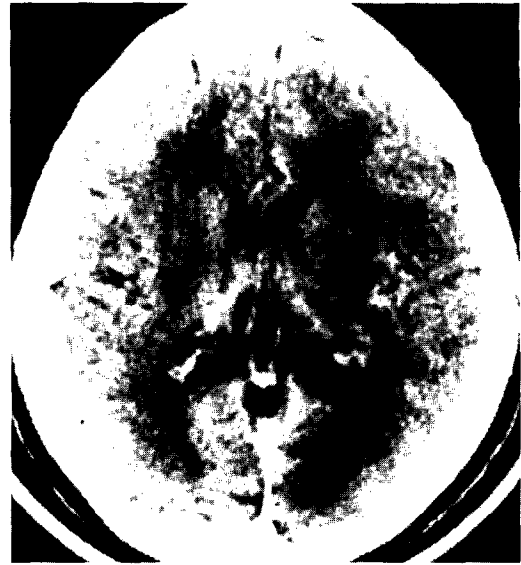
Axial brain CT shows a radiolucent area (infarct) extending from splenium (anteriorly) to visual cortex (posteriorly) on left side. Patient manifested alexia without agraphia (pure alexia) and right homonymous hemianopia. Visual acuity was normal.
